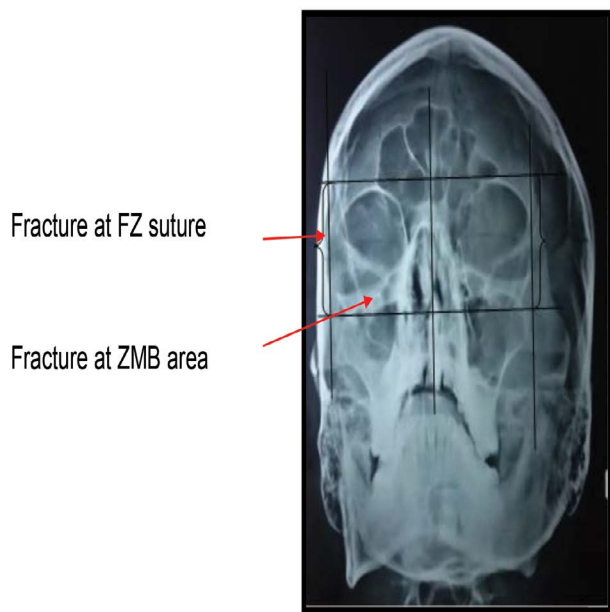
Showing preoperative radiograph.
